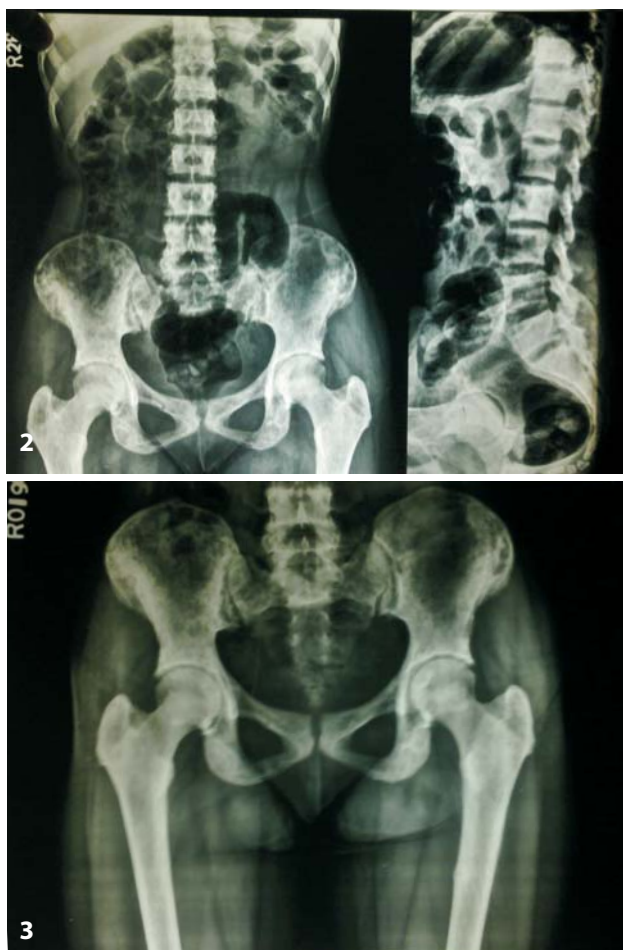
X-rays of pelvis showing typical changes of osteomalacia prior to treatment.
